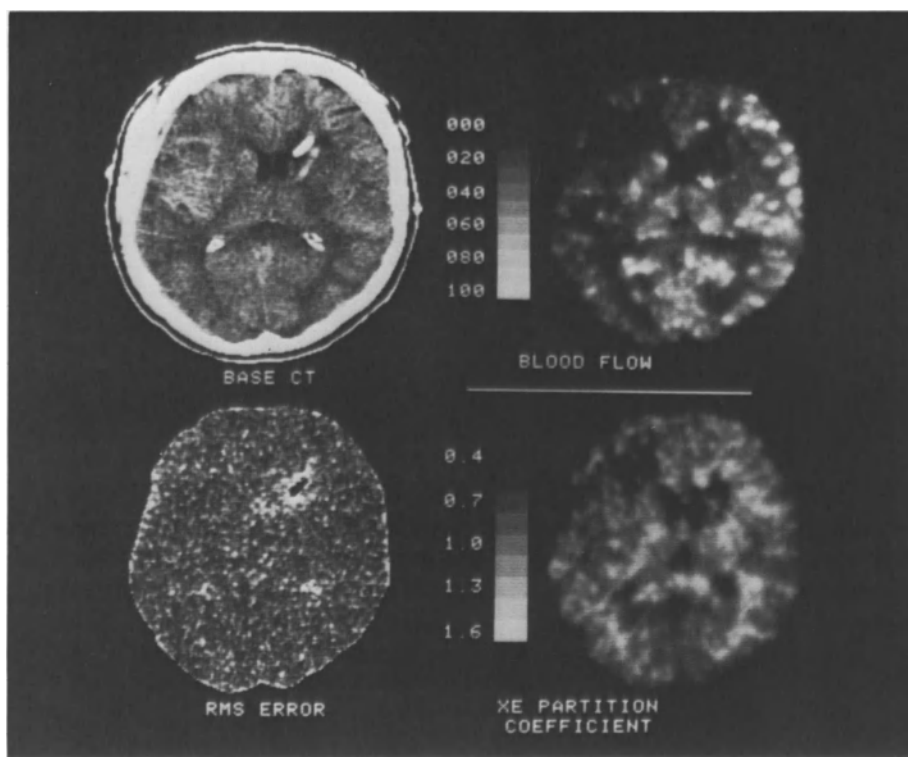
Matching CT/CBF studies, partition coefficient, and confidence image are displayed in a patient with a right middle cerebral aneurysm. The delayed onset of left hemiparesis is presumably due to vasospasm. Reduced right MCA flow values in the 20–40  $\text{cm}^3/100 \text{ g/minute}$  range are evident (upper right). This is a good quality study with CT artifact (RMS error) evident only near the ventricular catheter. The normal reversal of flow versus lambda (lower right) is evident with deep white matter retaining high lambda values ( $>1.0$ ) and low flows ( $< 30 \text{ cm}^3/100 \text{ g/minute}$ )
